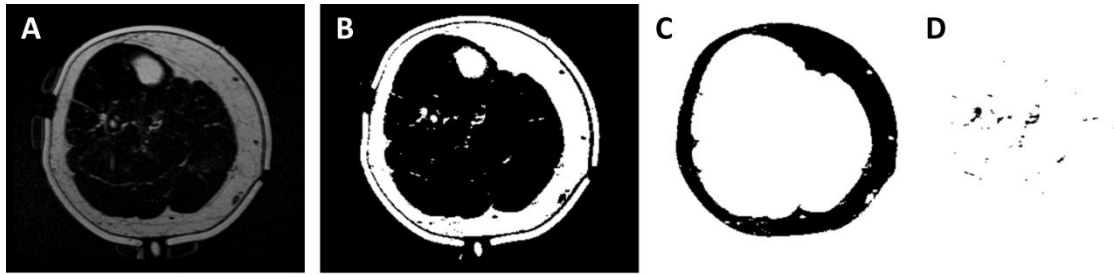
Processing of transverse MRI fat saturated slice of lower limb at posterior calf measurement site showing A: Original, B: Post-thresholding, C: Superficial adipose mask, D: adipose infiltrating muscle mask
